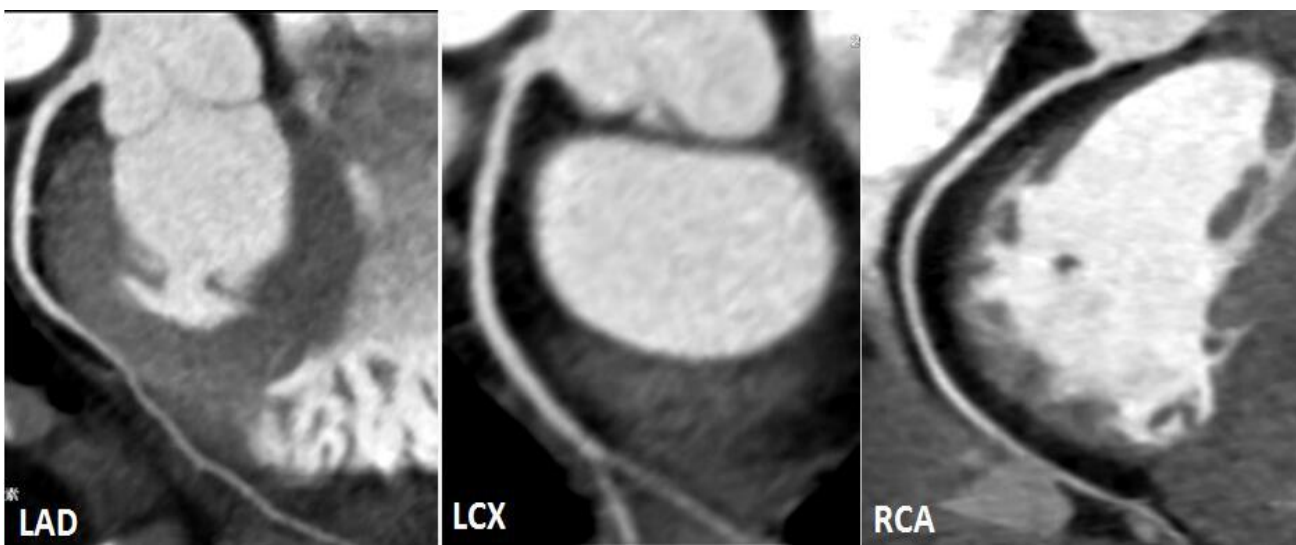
Emergency coronary artery computed tomography angiography performed 30 min after presentation showed no stenosis of coronary artery.
